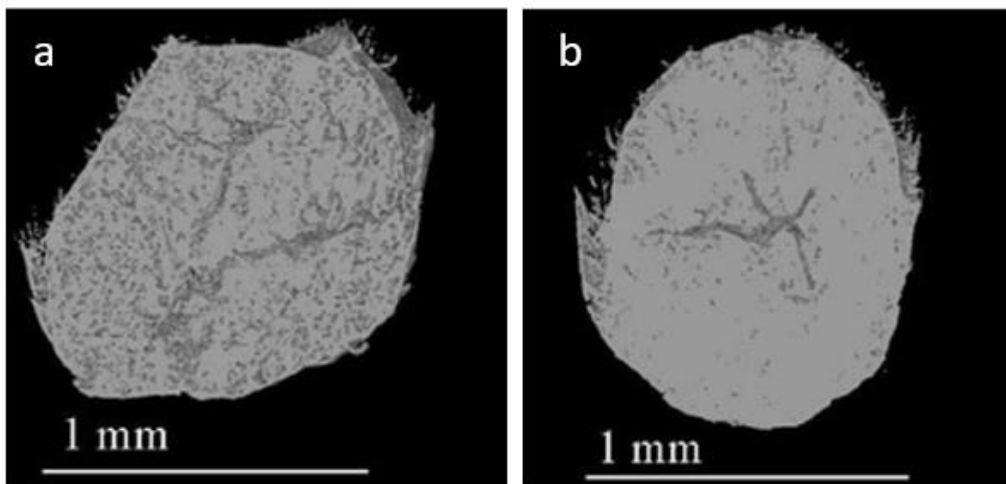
Reconstructed X-ray microtomography images showing cross-sections through MCC granules: (a) 3 min and (b) 15 min granulation time (MCC was granulated with water using a high shear granulator with a L/S ratio of 1.0) (Bouwman *et al.*, 2005)
